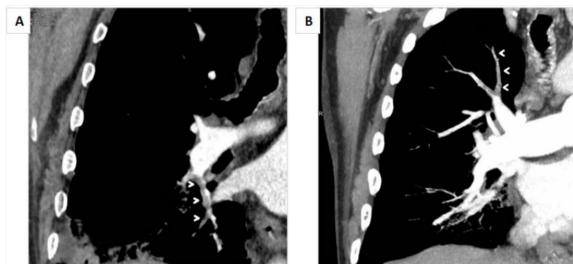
CT angiography of lungs. Note multiple small thrombus in the right middle lobe (panel A, white arrow heads) and right upper lobe (panel B, white arrow heads).
